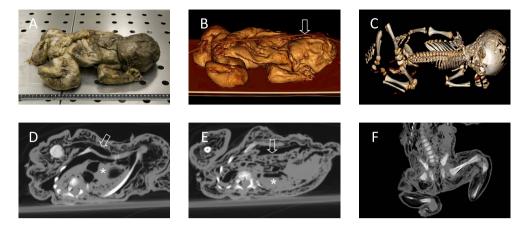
Neonate found several months after demise (case 1). Despite severe decomposition (scale VII) external features, such as the genitalia, are still present. Figure 1b. The neonate is scanned within the body bag (arrow points to the zipper), a surface shaded rendering of the soft tissue is routinely performed. Figure 1c. Also a 3D reconstruction of the complete neonatal skeleton is obtained. There is a normal fetal skeletal anatomy. The 'holes' in the skull are a result of the applied threshold and reflect the thin skull with a relatively low density on CT. Figure 1d. Axial slice at the level of the thorax shows extensive subcutaneous emphysema (arrow) and a massive amount of air in the right ventricle and atrium of the heart (RAI III, asterisk). Figure 1e. Axial slice at the level of the upper abdomen shows air in the liver (RAI III, arrow), the kidneys are not discernable (asterisk). Figure 1f. On a coronal-oblique reconstruction along the diaphysis of the left femur, the femoral length is measured.
